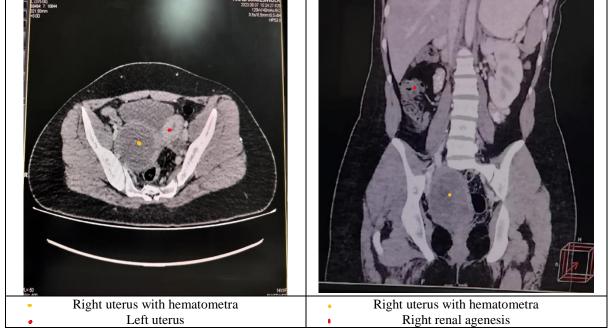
CT Scan images of OHVARIA Syndrome.
